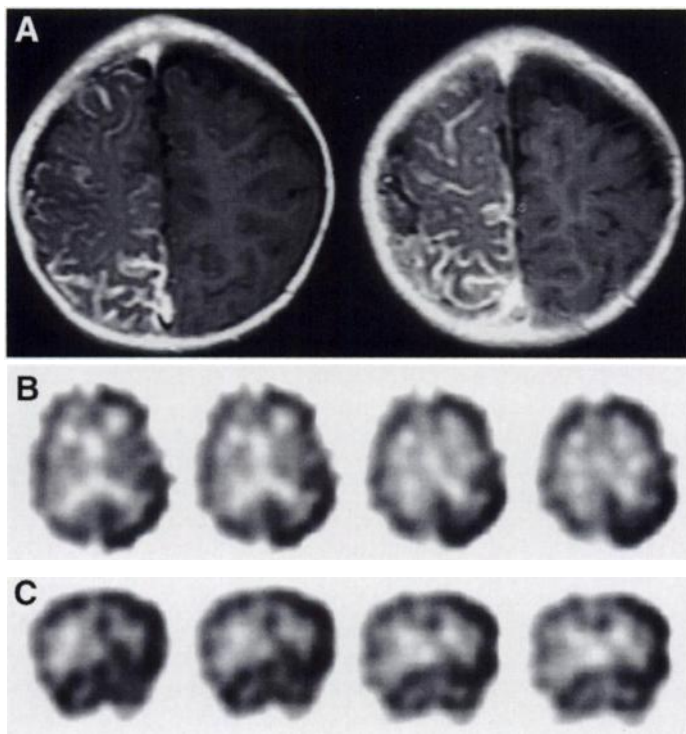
Gadolinium-enhanced, T1-weighted axial MRI (A) demonstrates right frontoparietal cortical atrophy and enhancement. Transverse (B) and coronal (C) ^{99m}Tc -HMPAO SPECT reveal globally diminished tracer localization in the right cerebral hemisphere.
